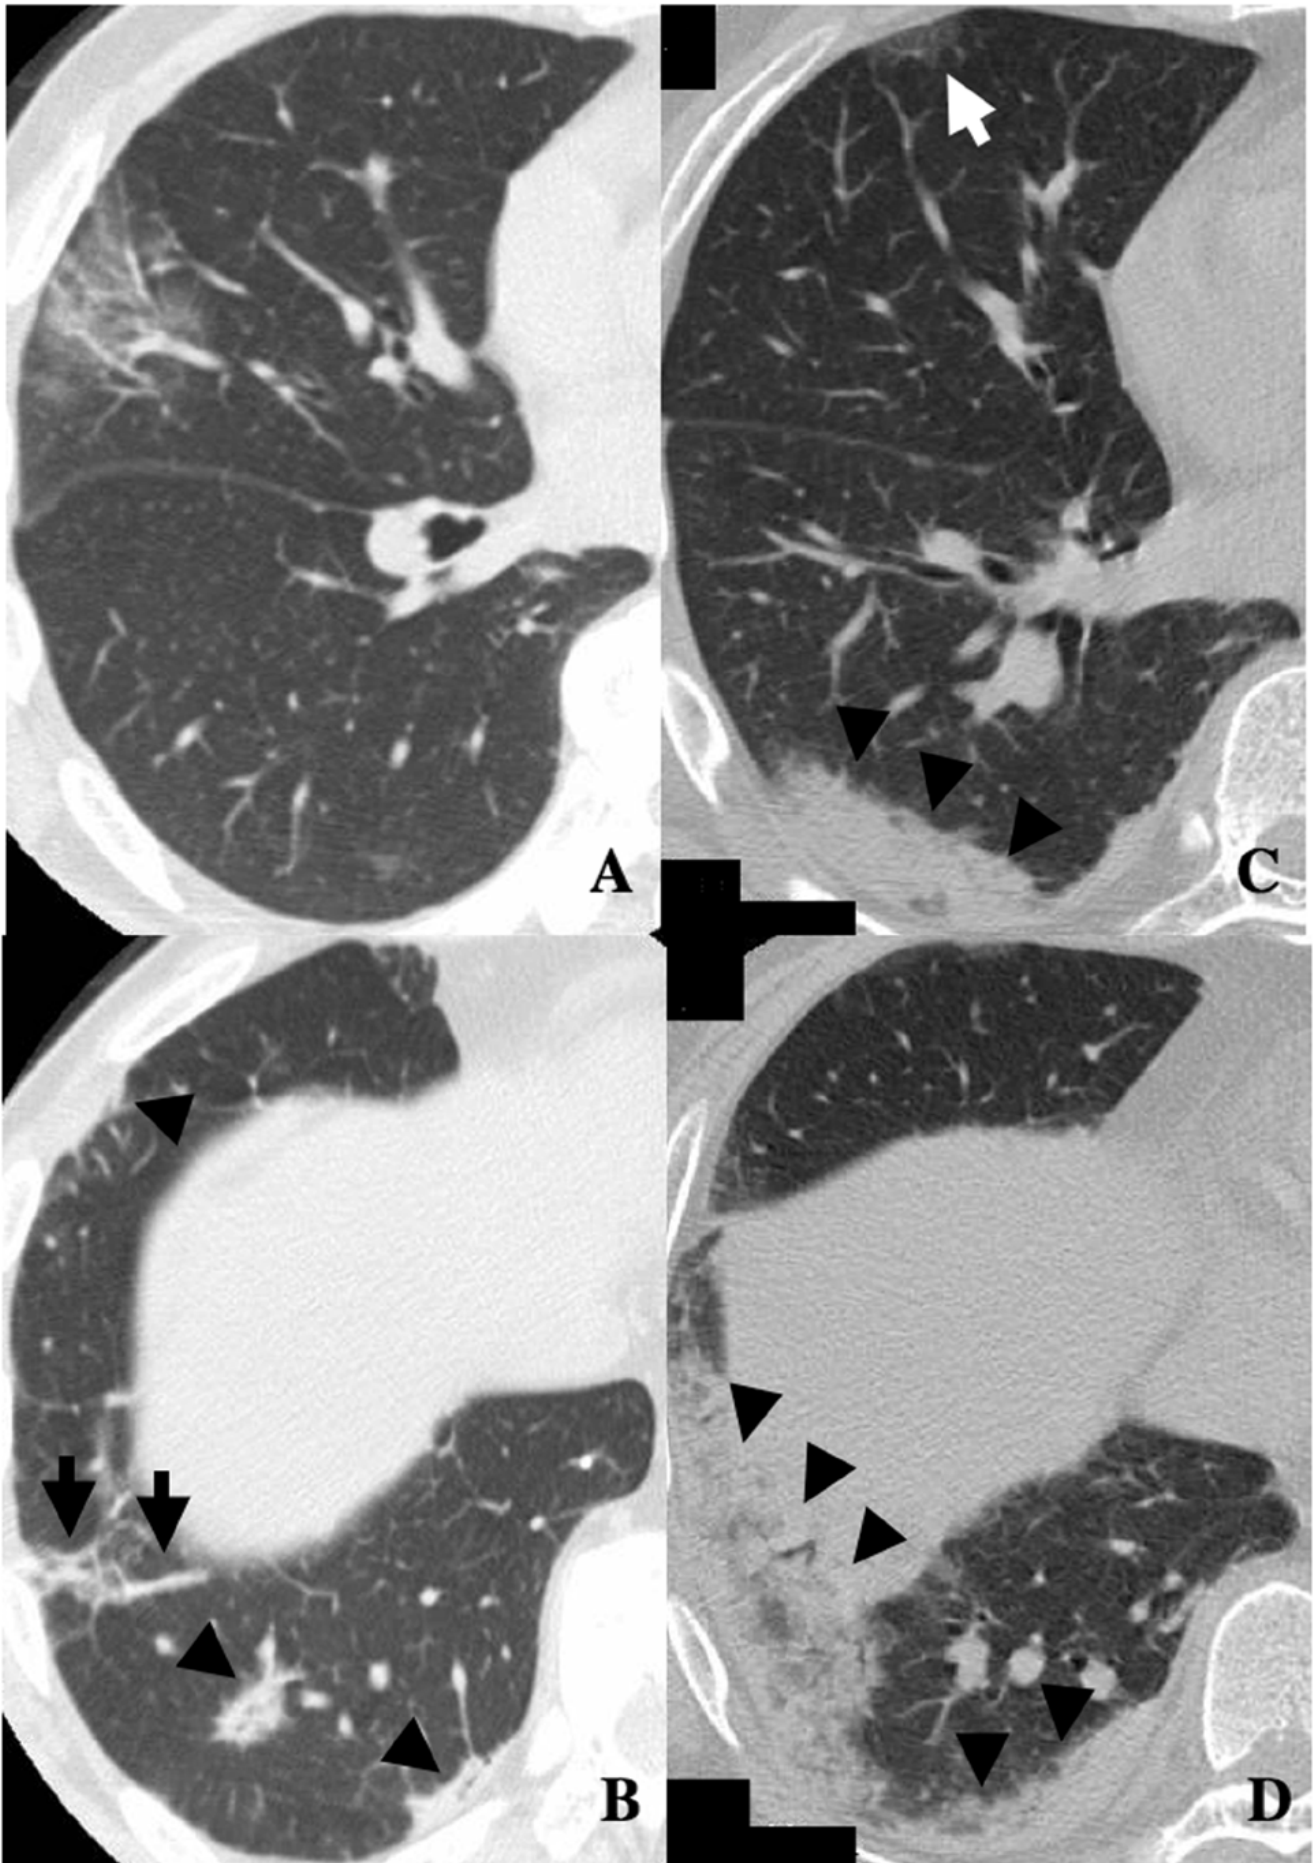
A and B: HRCT images showing lower consolidation/GGA pattern in a 51-year-old man positive for anti-CADM-140. A: At diagnosis, subpleural nonsegmental GGA was observed. B: Peripheral and peribronchovascular consolidations (arrowheads), and interlobular septal thickening and nonseptal linear or plate-like opacities (arrow) were also seen. C and D: HRCT images showing lower consolidation/GGA pattern in a 60-year-old man positive for anti-CADM-140. Subpleural nonsegmental consolidations with air bronchograms were observed (arrowheads). Subpleural nonsegmental GGA was also seen (arrow).
